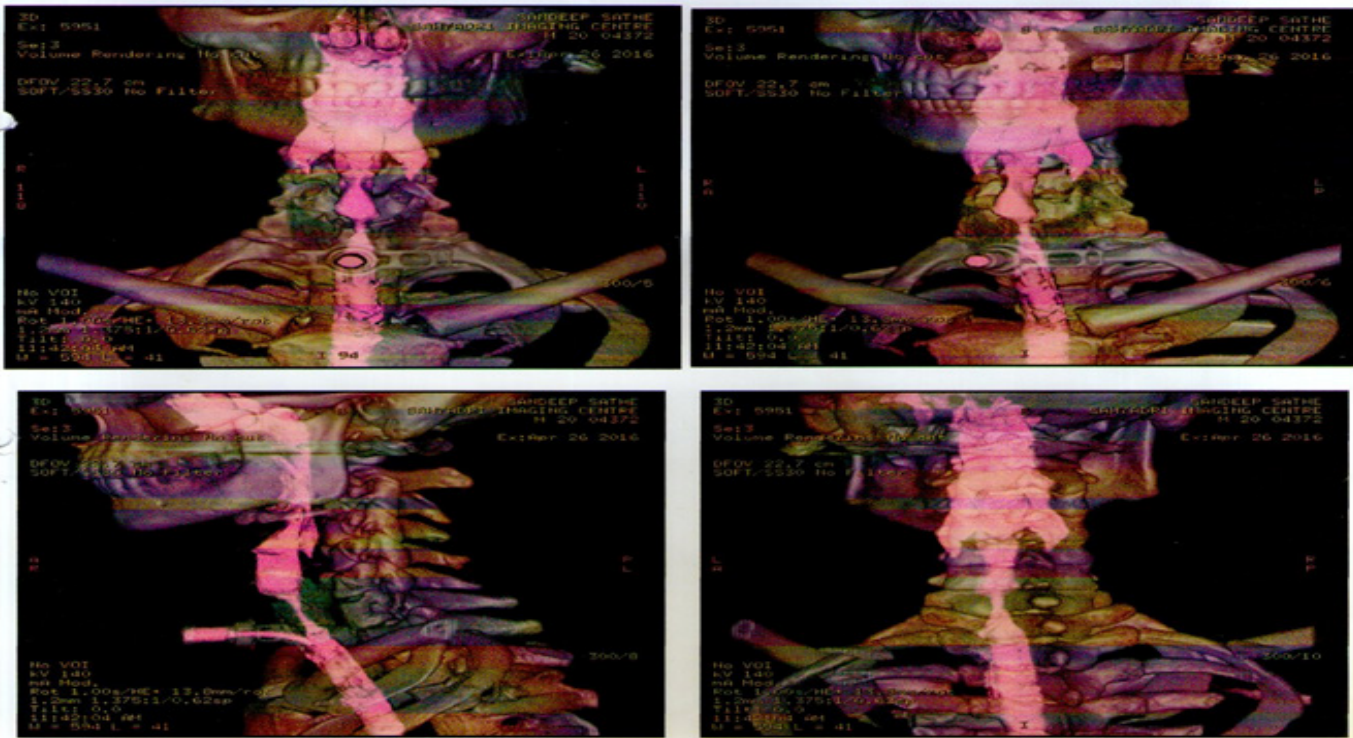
3D CT neck showing stenotic portion
